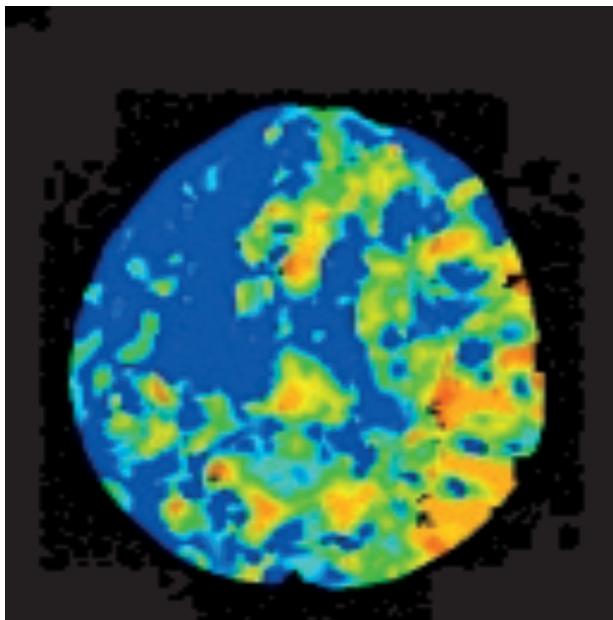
CT perfusion of massive CVI without penumbra
